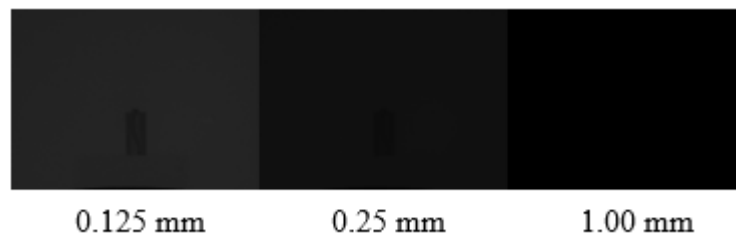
Typical radiographs that were acquired within the silver filter thickness of 0.125 mm to 1.000 mm, X-ray current of 100 μ A, X-ray tube voltage of 100 kV, FSD of 65 cm and X-ray exposure time of 1 sec.
